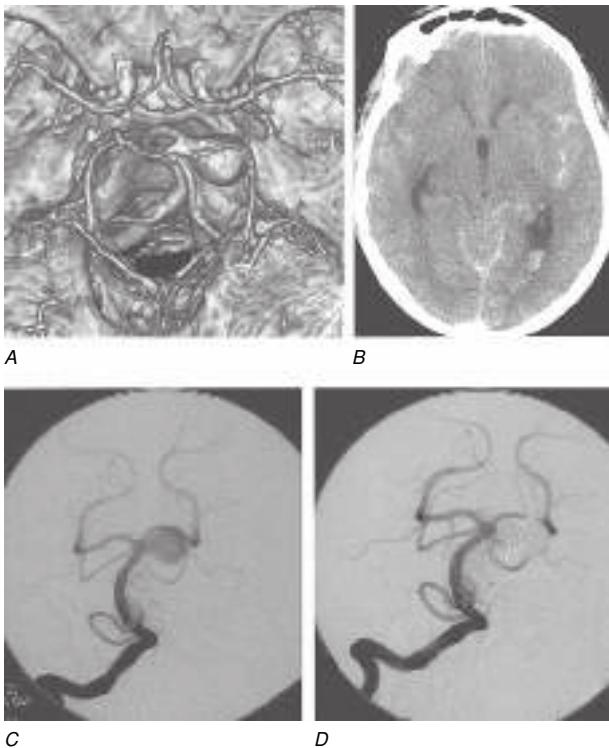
Subarachnoid hemorrhage. *A*, Computed tomography (CT) angiography revealing an aneurysm of the left superior cerebellar artery. *B*, Noncontrast CT scan at the level of the third ventricle revealing subarachnoid blood (bright) in the left sylvian fissure and within the left lateral ventricle. *C*, Conventional anteroposterior x-ray angiogram of the right vertebral and basilar artery showing the large aneurysm. *D*, Conventional angiogram following coil embolization of the aneurysm, whereby the aneurysm body is filled with platinum coils delivered through a microcatheter navigated from the femoral artery into the aneurysm neck.
